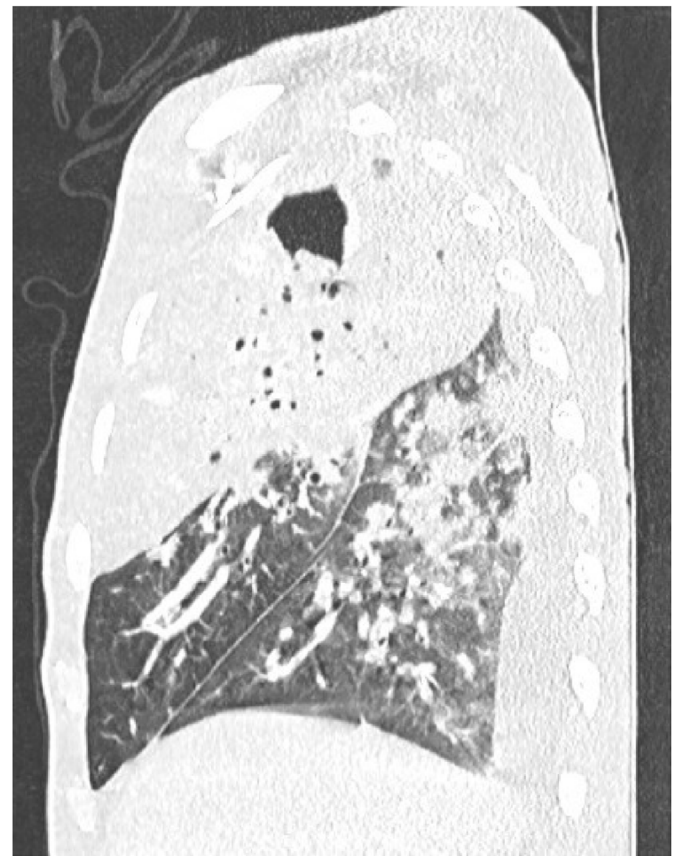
CT scan in sagittal parenchymal window reconstruction: Alveolar condensations taking the right upper lobe with an excavated lesion and an air bronchogram, the lower lobe. Thickening of the septal lines.
